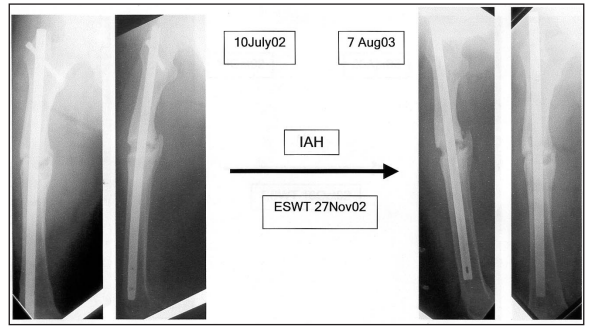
Radiographs before and after ESWT for patient IAH
